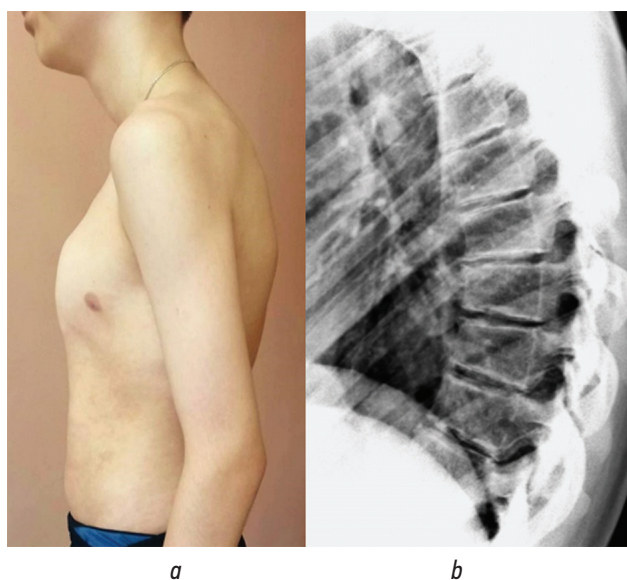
Appearance (a) and results of chest X-ray (b) of a 14-year-old adolescent with pectus carinatum and Scheuermann's disease
